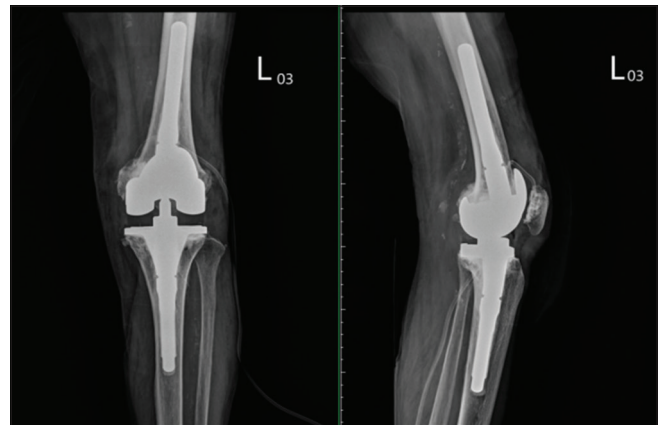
Postoperative radiographs of revision total knee arthroplasty with Legacy Constrained Condylar Knee
